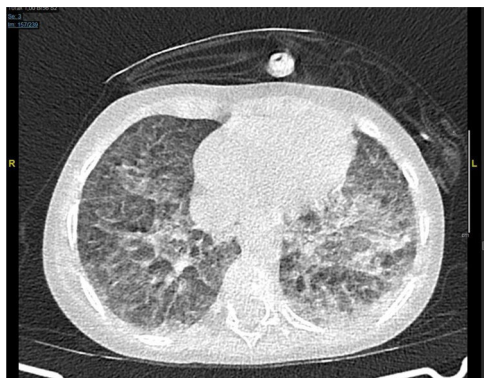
Thoracic CT scan with bilateral ground-glass opacities.
